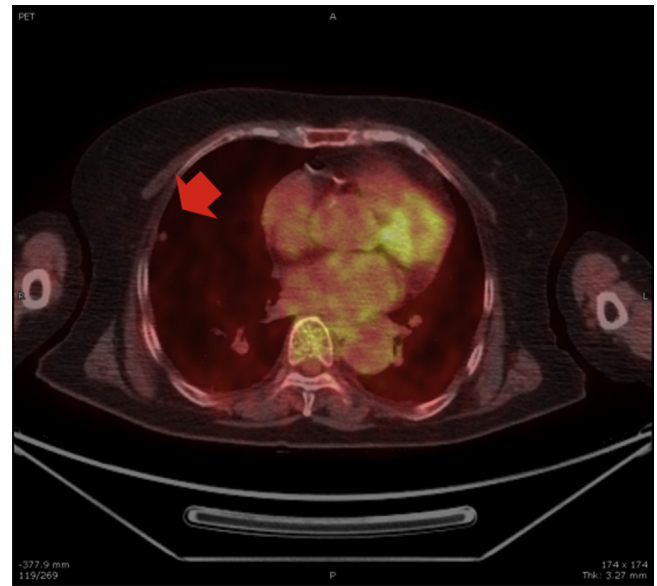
Positron emission tomography/CT images show the low signal accumulation of signal in a pulmonary nodule (arrow).
